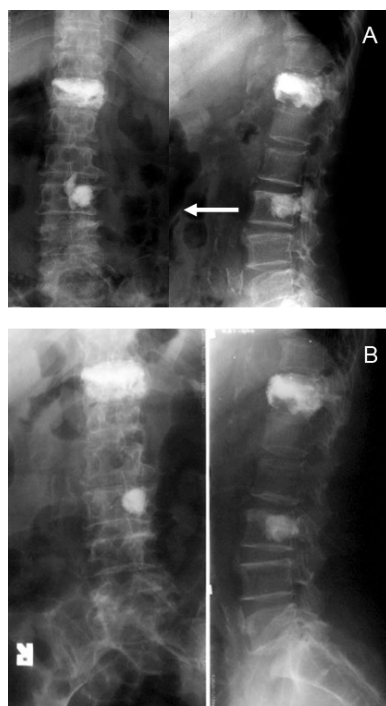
A 61-year-old woman with osteoporotic vertebral compression fracture T12 and L3. She underwent vertebroplasty on both levels. She developed leg pain after the operation. (A) X-ray shows spinal canal leakage of cement (white arrow). (B) After surgical removal of cement
